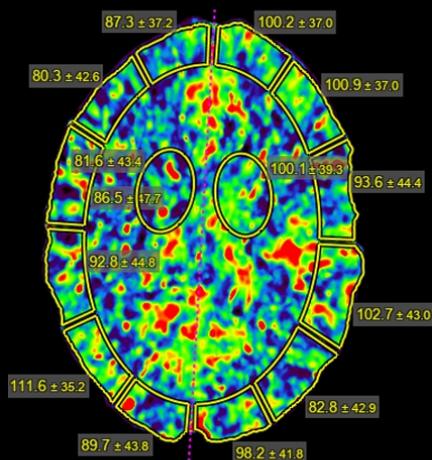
66yo F, Left hemiparesis. Initial CT ASPECT of 7 (A). Large volume of increased TTP (B). Follow up CT scan at 4 weeks (C).
